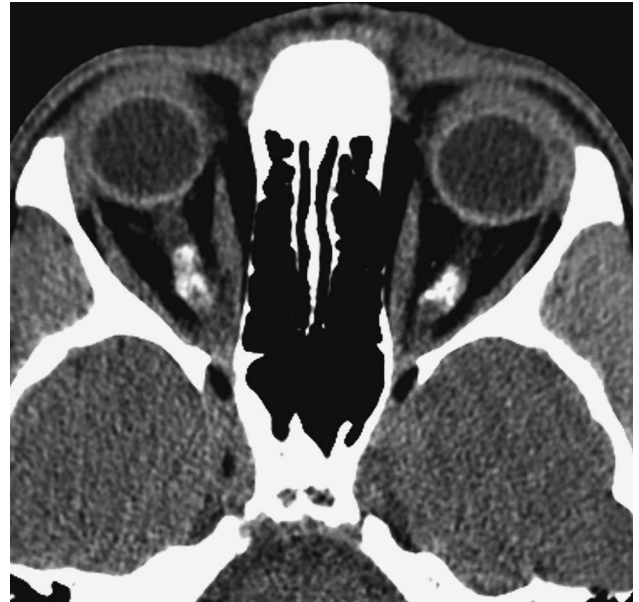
Precontrast axial CT reveals thickening and calcification in the region of the orbital optic nerves bilaterally.
